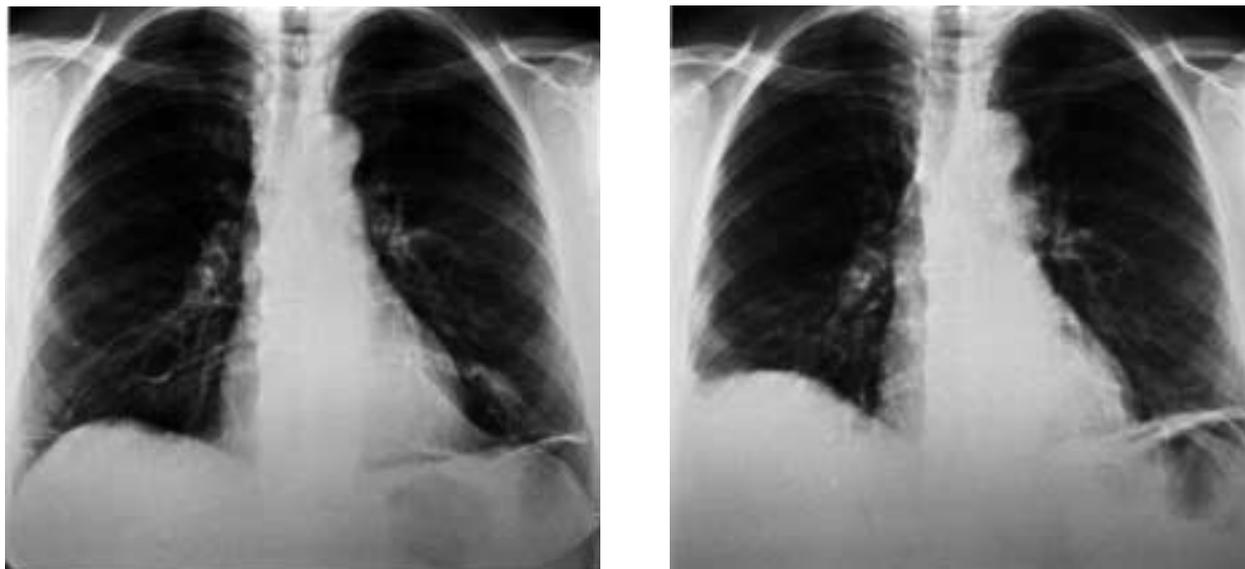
Chest radiographic images taken in a municipal health care centre. a) Bilateral thin atelectases are seen in the chest radiograph taken on March 2, 1993. A pneumonic infiltrate is seen anteriorly on the left side. b) In the chest radiograph taken on March 12th 1993, the right diaphragm is elevated, a small amount of fluid is seen in the right lateral corner, and the atelectasis on the left side is accentuated.
